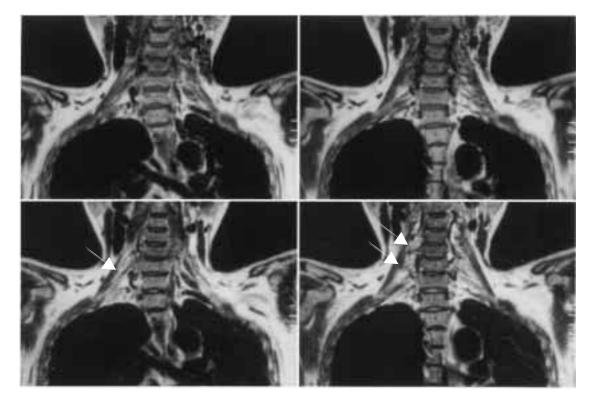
T2-weighted MR images showed high signal intensity along the right brachial plexus and soft tissue masses (*lower*, *arrow*), although T1-weighted MR images were equivocal (*upper*).
